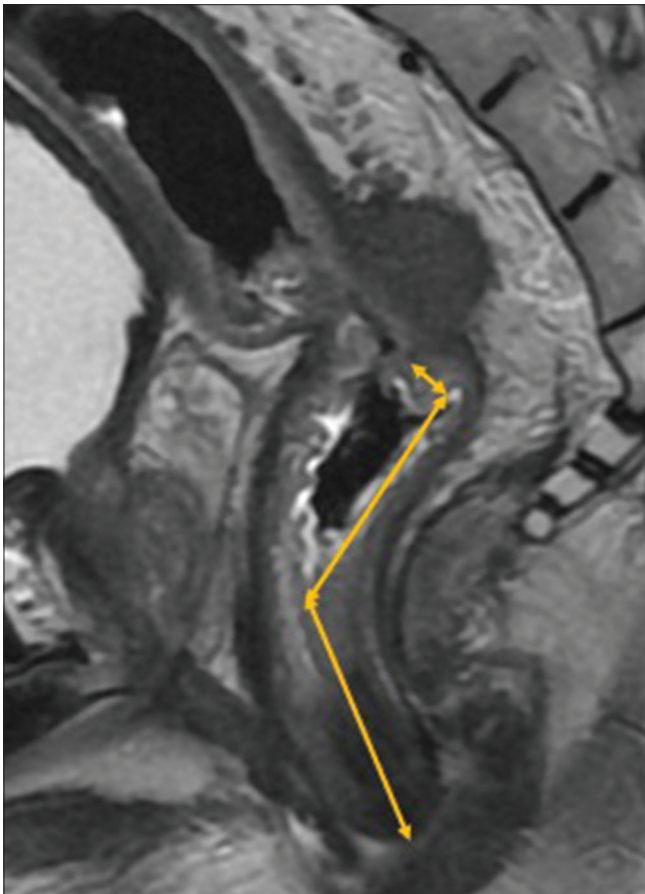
Measurement of length of tumor involving the anal canal and lower rectum on sagittal T2-weighted image
